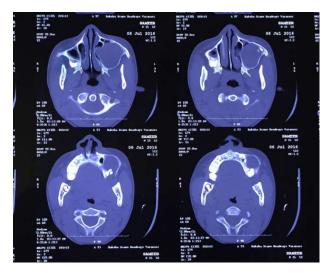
CT sections revealing monocortical buccal expansion and also expansion of anterior wall of maxillary sinus. CT also revealed haziness and complete obliteration of left maxillary sinus and it also contained an impacted tooth
